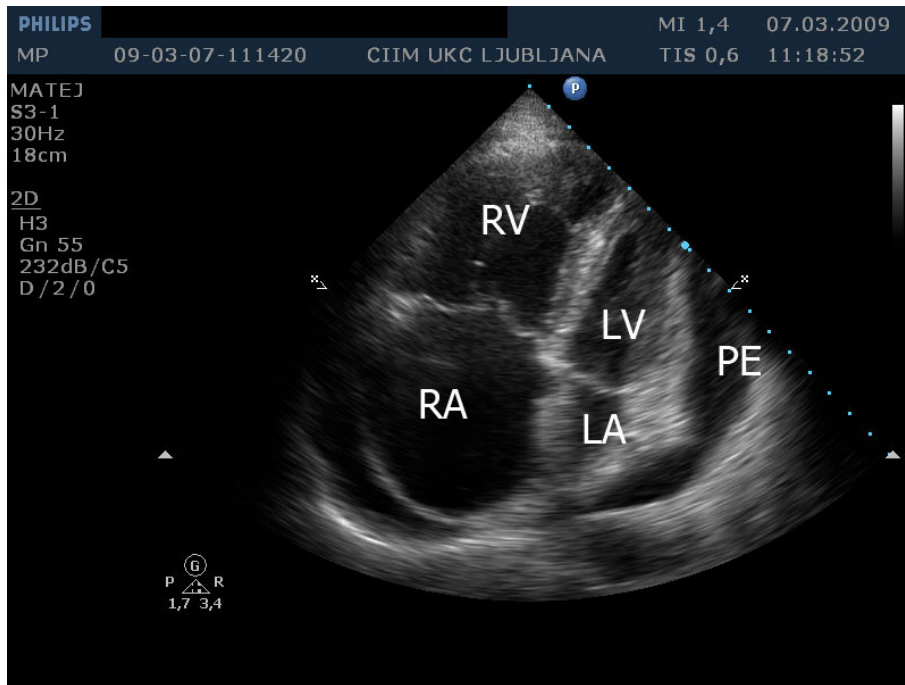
Transthoracic echocardiography from apical four chamber view shows enlarged right ventricle (RV) and right atrium (RA). There is pericardial effusion (PE) compressing left ventricle (LV) and left atrium (LA).
